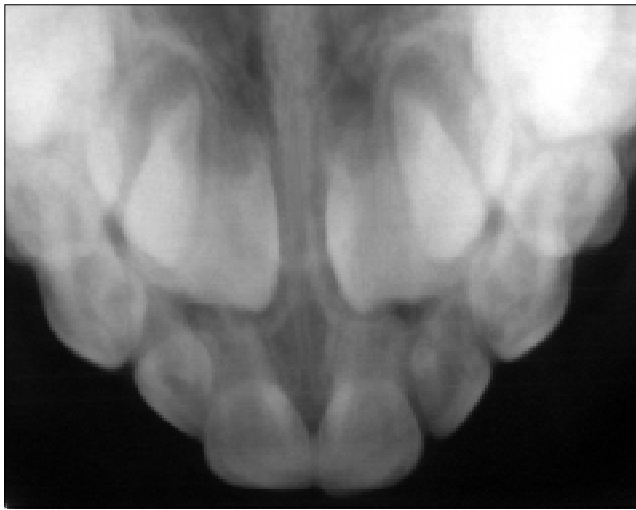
Radiograph of maxillary teeth indicate no pathosis in periapical region
